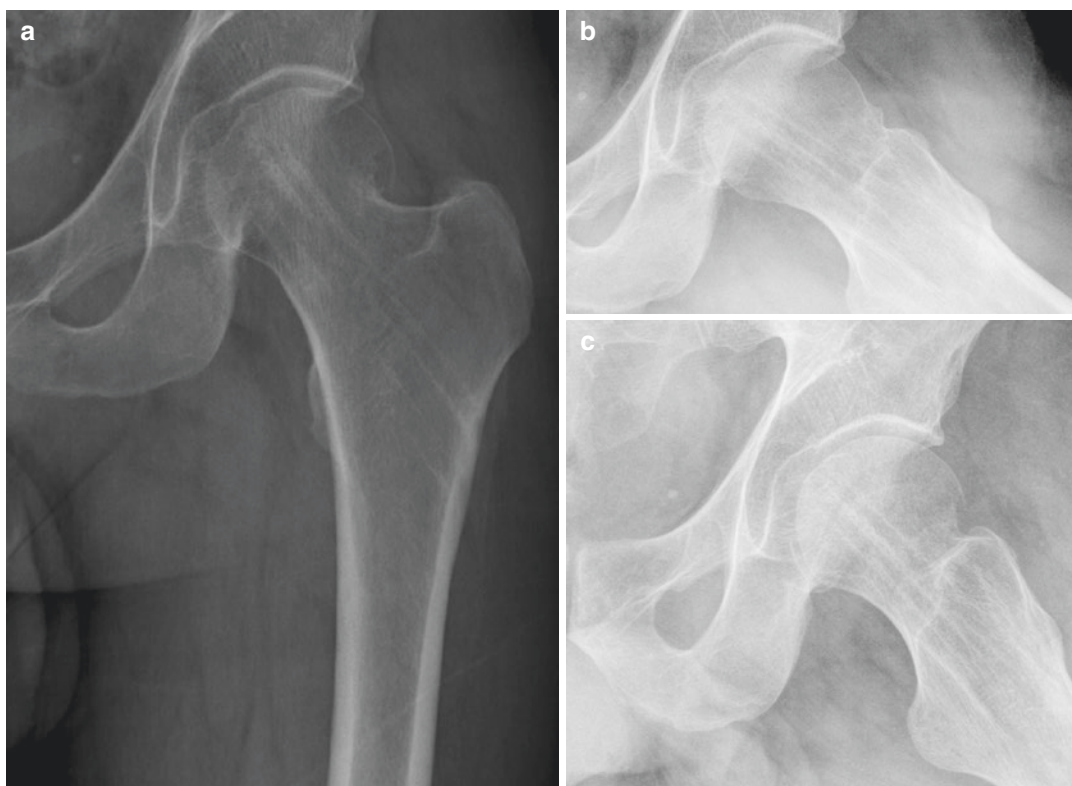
(a) X-ray showing a consolidated subcapital neck femur fracture 2 years after the fracture and 1 year after screws' removal. (b) X-ray showing an excessive
